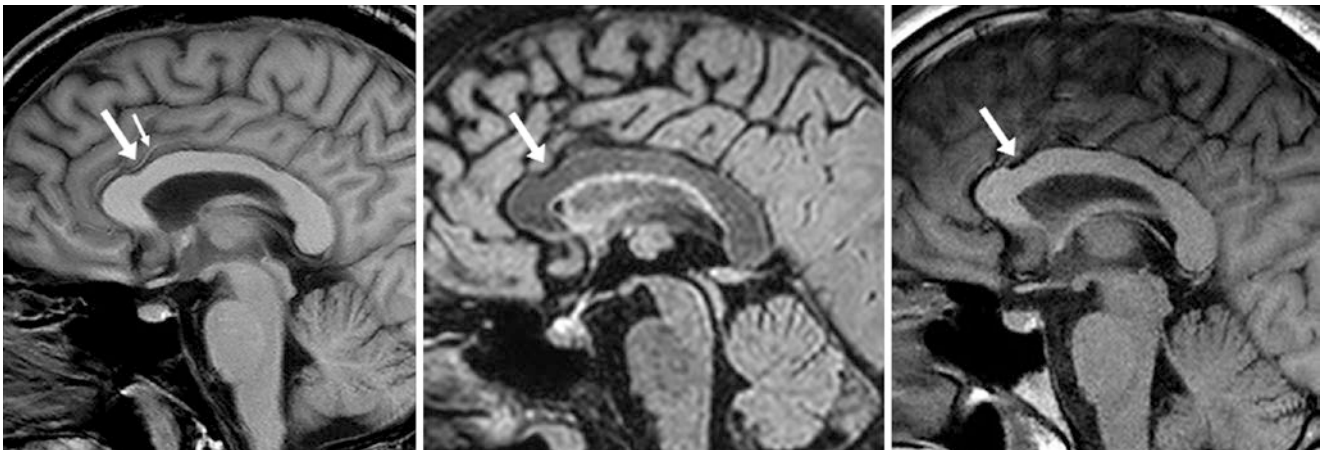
A 33 year old with a negative 3T MRI demonstrating normal compression of the posterior genu–anterior body of the corpus callosum (arrows) on a sagittal midline T1WI (left) and FLAIR image
